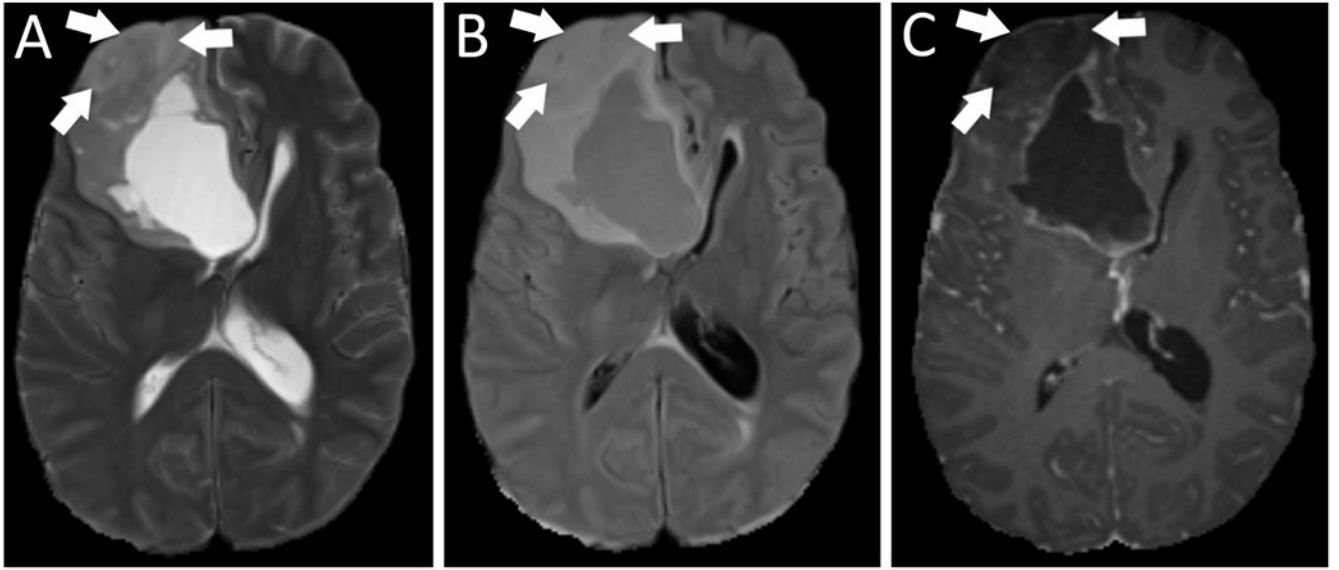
A non-enhancing solid component that does not meet the criteria for partial T2-FLAIR mismatch extends to the right frontal cortical gray matter anteriorly (arrow) in an IDH-mutant case on T2-weighted (A), FLAIR (B), and postcontrast T1-weighted images (C).
